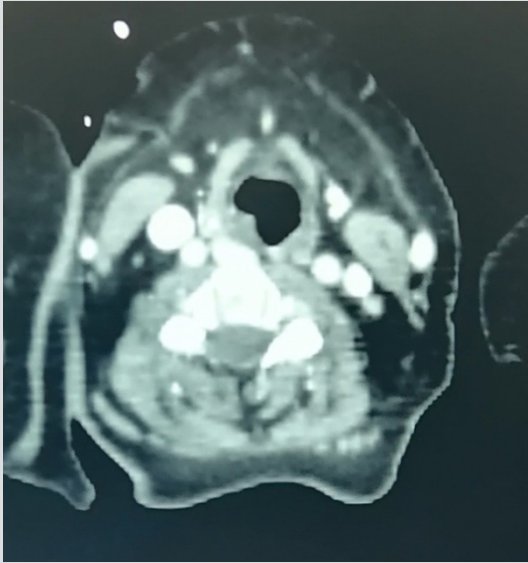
Computed tomography, axial section showing the obstructive lesion
